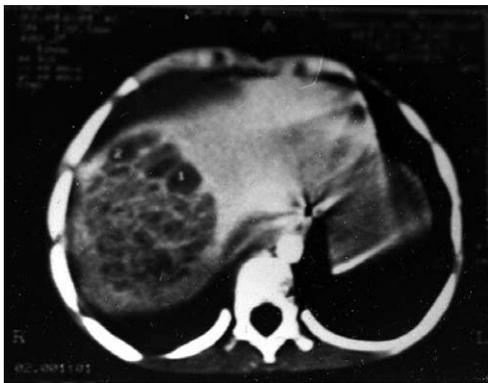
Computed tomography scan picture showing abscess in the right lobe of the liver.
